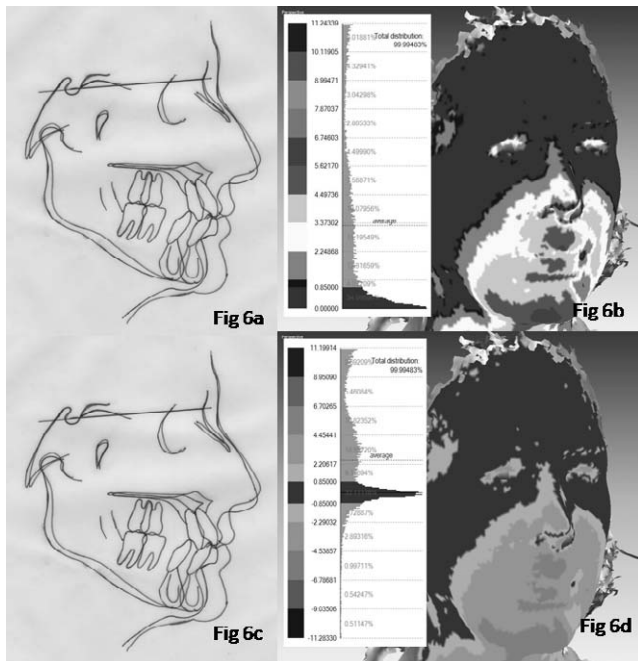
Subject B a) and c) Changes on the lateral cephalometric radiograph showed soft tissue changes. b) and d) The 3D superimposition revealed how the same landmarks moved forward.
